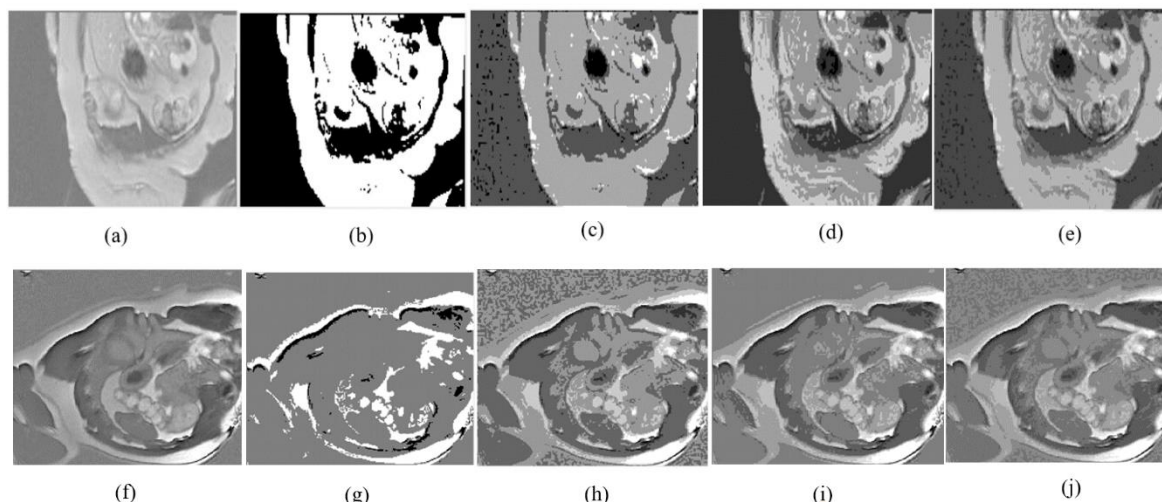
Samples of the scaled images with reduced number of intensity values (only 8) and different grey levels; (a) Normal original MRI slice, (b) normal scaled image with 3 grey levels, (c) normal scaled image with 6- grey levels, (d) normal scaled images with 9- grey levels, and (e) normal scaled images with 12-1 grey levels, (f) Pathology original MRI slice, (g) pathology scaled images with 3- levels GLCM image, (h) pathology scaled images with 6- grey levels, (i) pathology scaled images with 9- grey levels, and (j) pathology scaled images with 12- grey levels.
